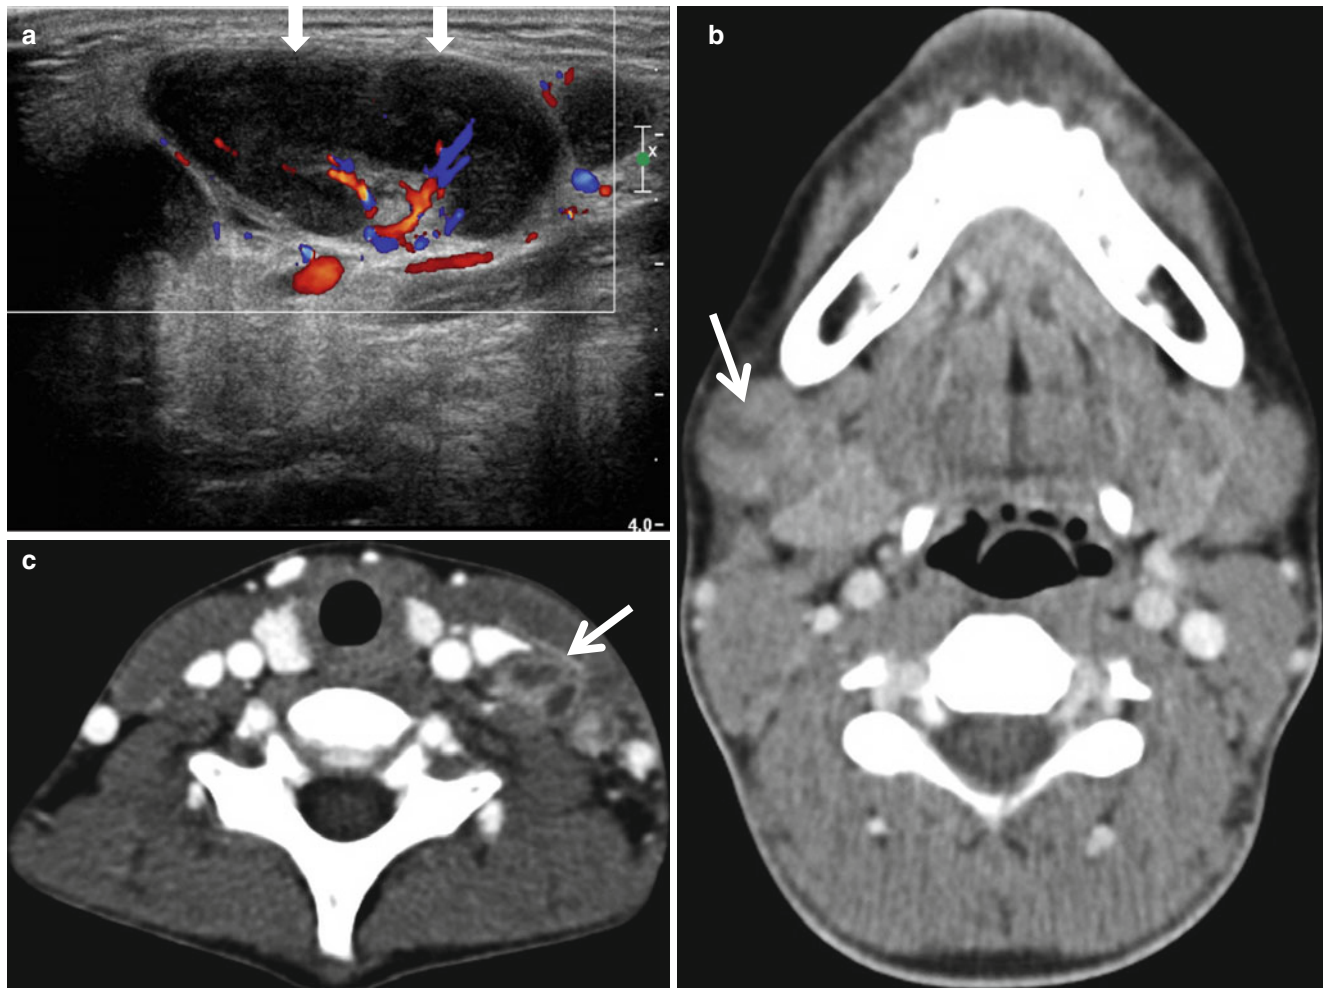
Kikuchi disease in a 13-year-old boy. (a) Color Doppler ultrasound of the right submandibular region shows a large enlarged lymph node (arrows) with profound hypoechoogenicity and increased central vascularity. (b, c) Postcontrast CT through submandibular gland (b) and thyroid gland (c) show enlarged lymph nodes with internal low
